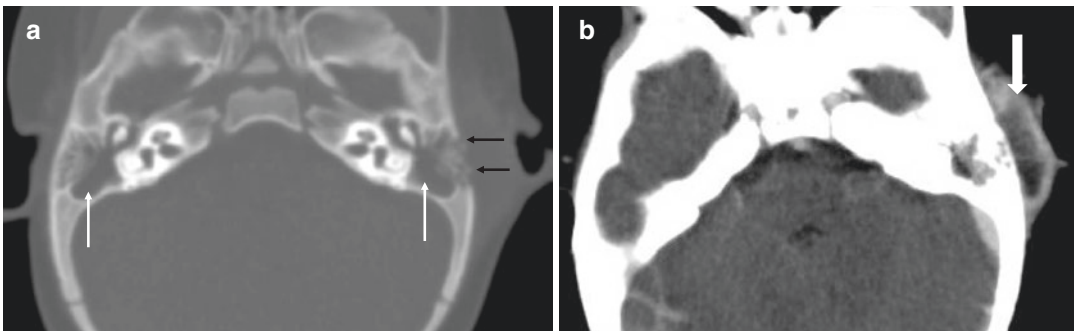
(a) Axial CT bone window showing bilateral mastoid opacification (white arrows) and cortical erosions of the outer cortex of left mastoid (black arrows). (b)
